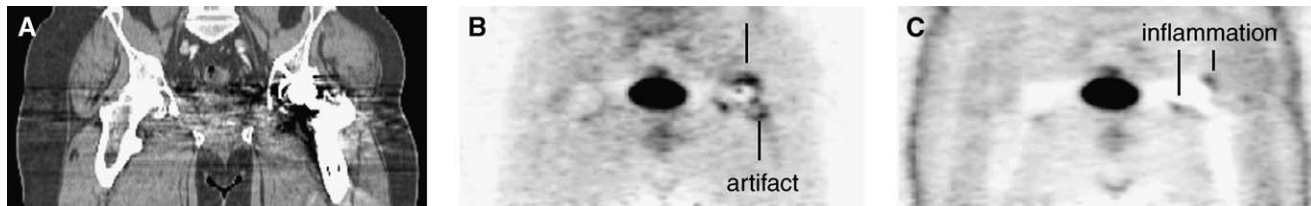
High-density metal artifacts, such as hip implants, cause streak artifacts on CT (A), which may translate into tracer uptake patterns on corrected PET images (B). These artifacts are not seen on the uncorrected emission images, which display residual activity only, likely to be caused by inflammation.
